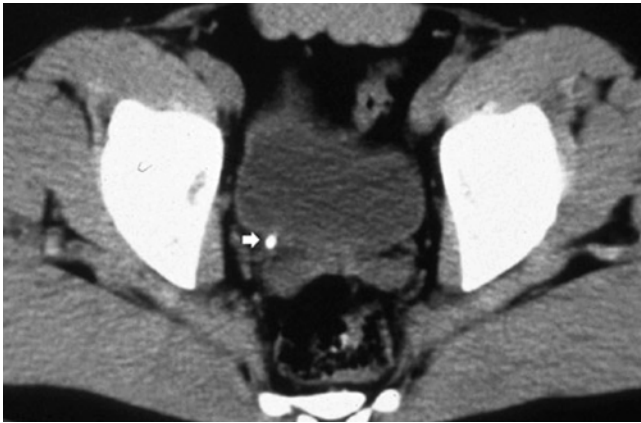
Unenhanced CT image demonstrating a ureteral stone (*arrow*) in the distal right ureter
